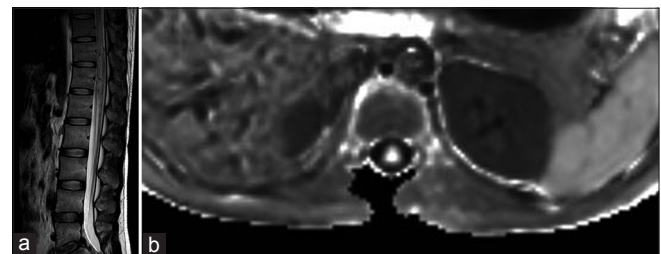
(a) Magnetic resonance imaging of dorsal spine after 1 month follow-up showing central T2 hyperintensities of the cord. (b) Diffusion-weighted imaging of the spine showing restricted diffusion
